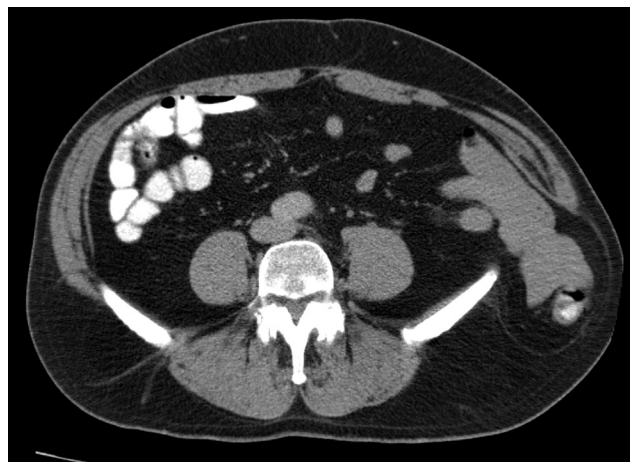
Representative image of abdominal computed tomographic (CT) scan demonstrating a 5.8 cm hernia.
